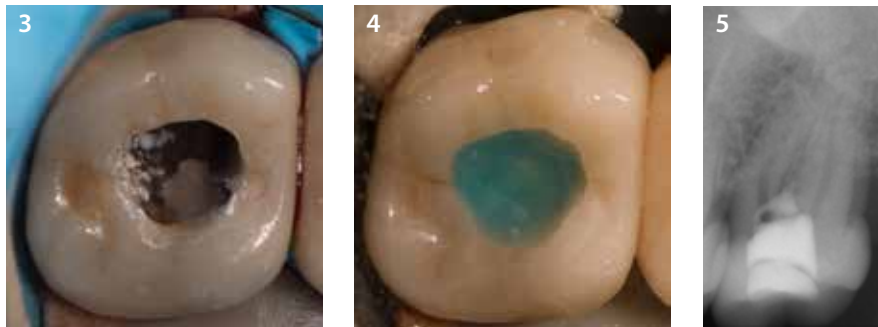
X-ray of the perforation closure after the first appointment
